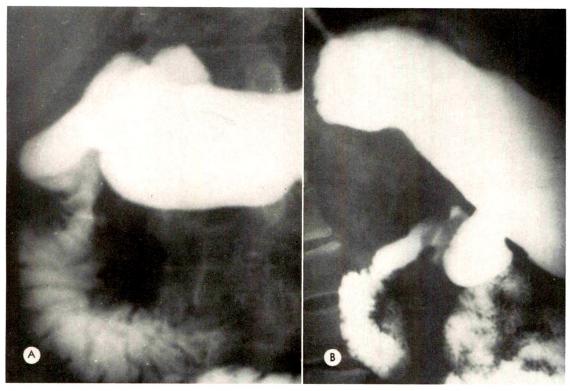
(A and B) Carcinoma of the head of the pancreas. The frontal roentgenogram shows no abnormality on the concave side of the descending duodenum, but there is a nodular defect on the convex side with fixation and divergent separation of the folds. The lateral roentgenogram presents enlargement of the retrogastric and retroduodenal space. (Note differential displacement of descending duodenum.) Bulbar defect with ulceration is present.
